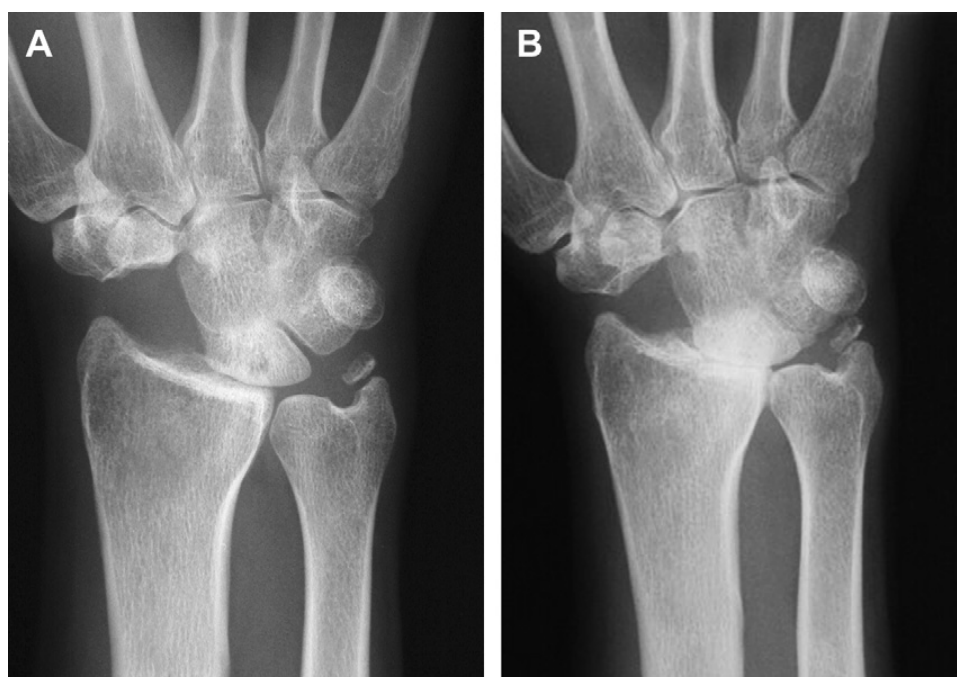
Anteroposterior radiographs after scaphoid excision and four-corner fusion (A) at the time of radiographic arthrodesis and (B) 5 years postoperatively showing advanced adjacent arthritis of the radiolunate joint.
